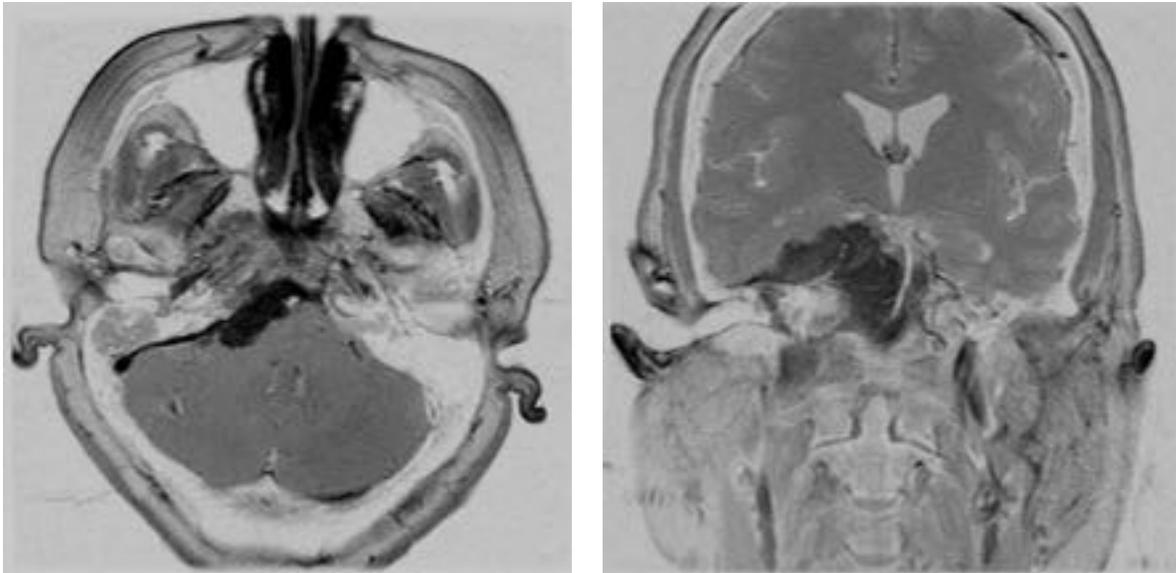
(continued) Massive right petroclival meningioma presenting with a fluid sensation and hearing loss in the right ear. This massive tumor extends from the optic chiasm to the jugular foramen. (C) Axial magnetic resonance imaging (MRI) showing obstructive serous otitis media due to disease within the middle ear. (D) Coronal MRI showing displacement-encasement of the basilar artery. The tumor encircles the entire bony labyrinth.
